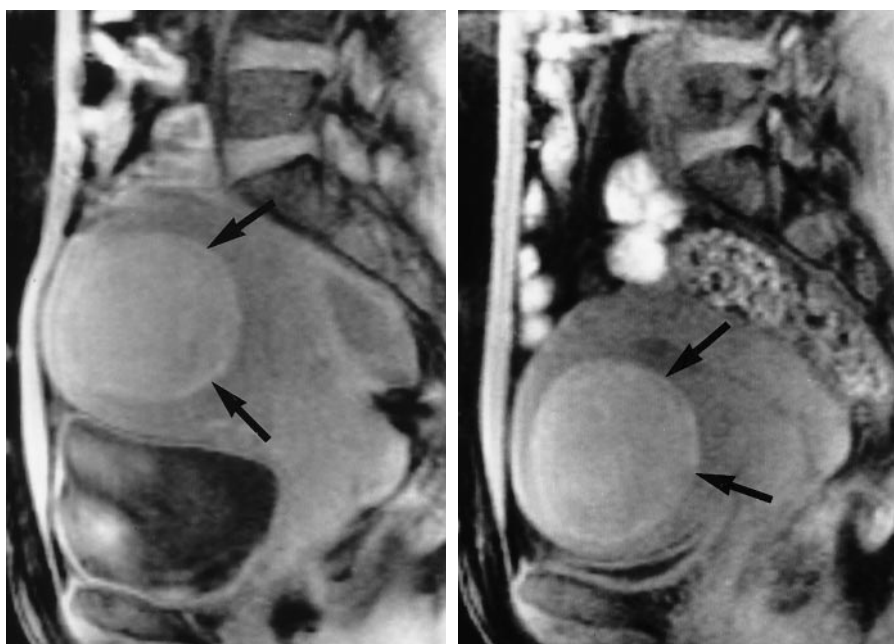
Sagittal T1-weighted two-dimensional fast low-angle shot MR images (180/4.8, 75° flip angle, 256 × 106 matrix, 300 × 300-mm field of view, 8-mm-thick sections) obtained (a) before and (b) after embolization show little change in fibroleiomyoma (arrows) volume. Thus, initial high signal intensity on T1-weighted images is predictive of a poor response to embolization.
